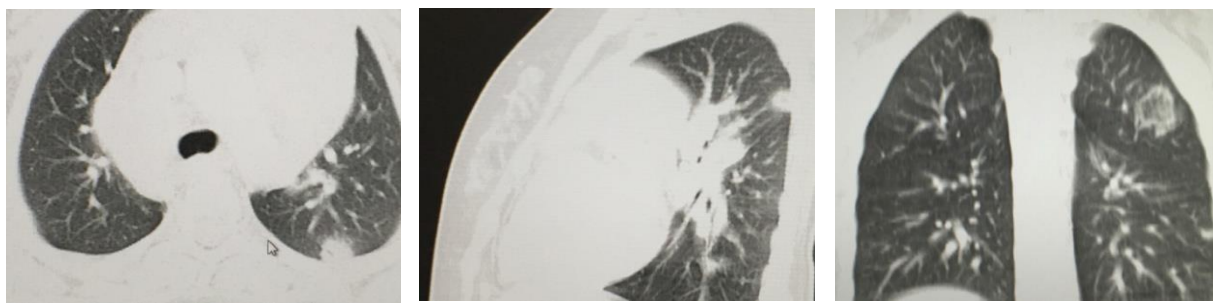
(C): Follow up CT after 3 months (the patient did not receive any treatment) there were stationary course regarding the size (according to clinical and radiological data, the patient was considered true negative).
